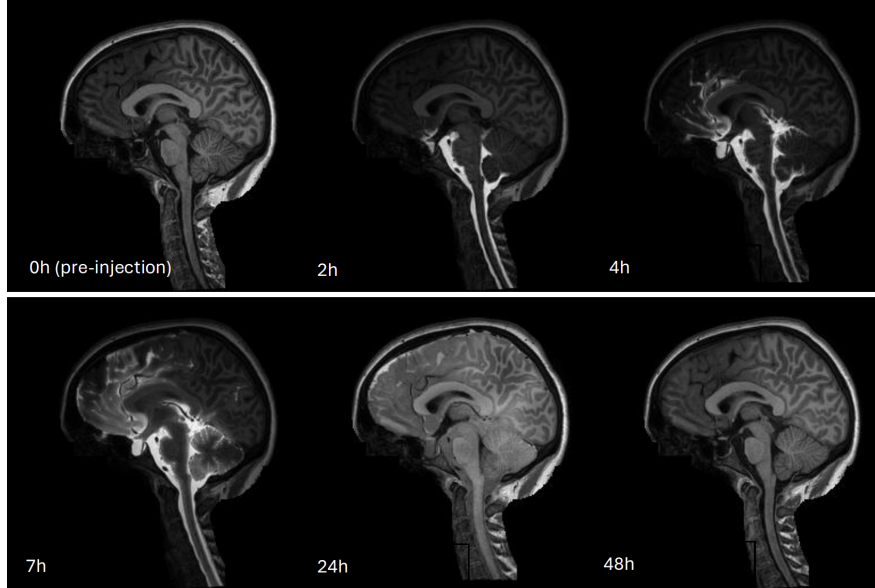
Defaced sagittal slices from CSF tracer-enhanced MRI of a sample patient. After 24 hours, the tracer has enriched the CSF spaces around the entire brain and is completely cleared after four weeks.
